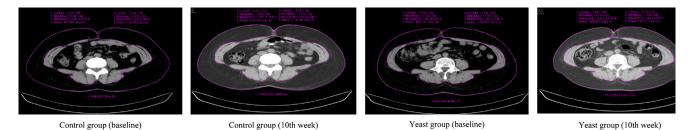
Abdominal fat measured by computed tomography (CT) before and after 10 wk of treatment.
